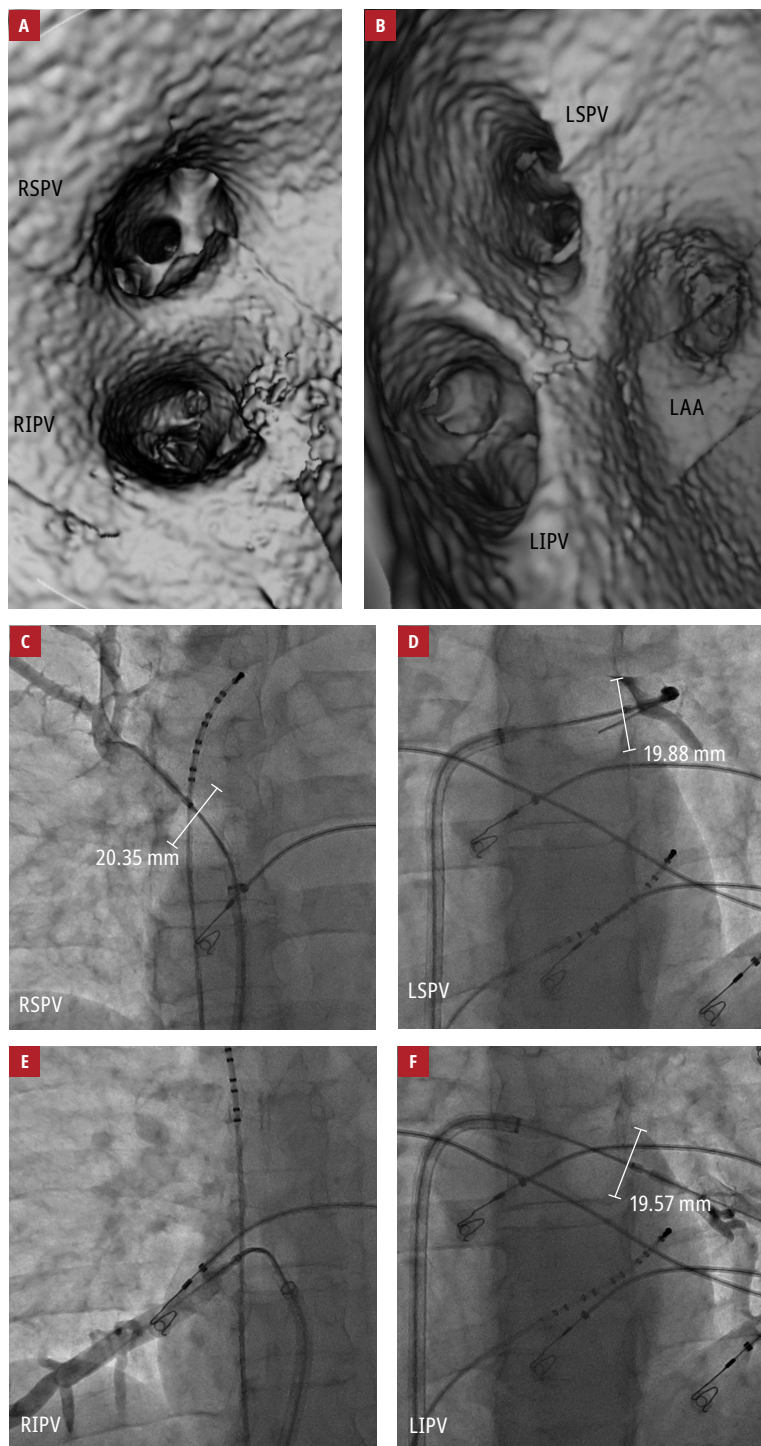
A, B – 3-dimensional computed tomography showing the reconstruction of the right (A) and left (B) pulmonary veins; C–F – cryoballoon adhesion in the pulmonary vein ostia assessed with contrast venography
